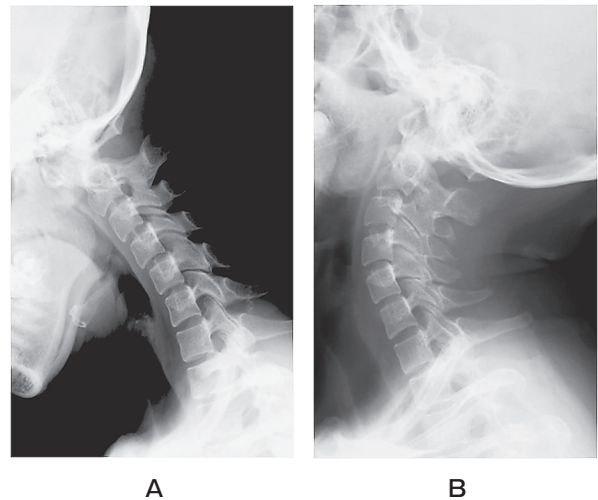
Preoperative lateral radiographs. Lateral, dynamic radiographs reveal a reducible atlantoaxial subluxation. The atlantodental interval was 10 mm at flexion (A) and 0 mm at extension (B).
